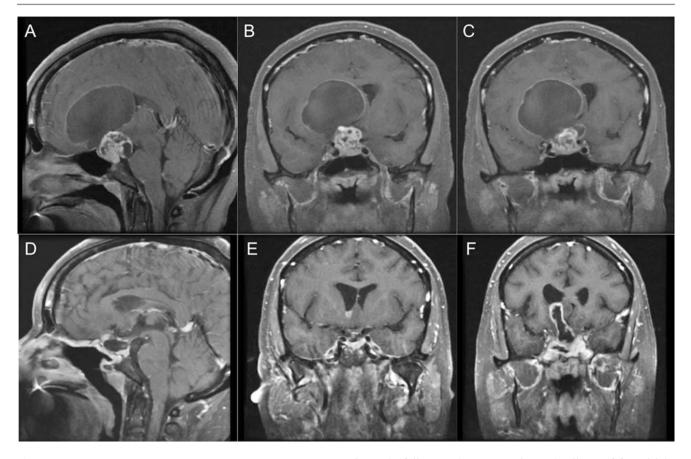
(a–c) Preoperative MRI of solid retrochiasmatic craniopharyngioma with associated giant right frontal lobe cyst. Removal of the solid retrochiasmatic component was performed with wide fenestration of frontal lobe cyst into suprasellar cistern. (d–f) Postoperative MRI at
